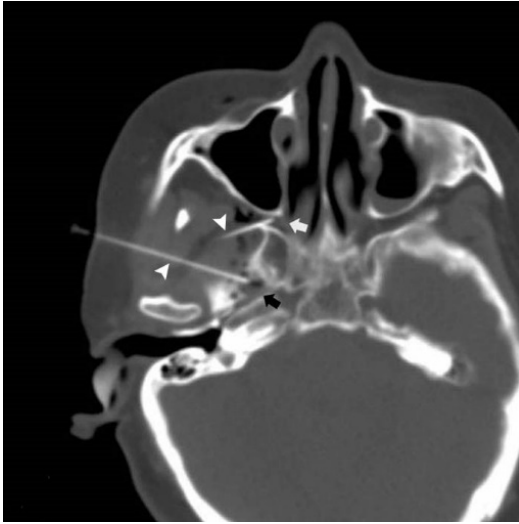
Axial computed tomography (CT) image showing the needle (White arrowhead) tip at the pterygopalatine fossa (PPF) (White arrow) and foramen ovale (FO) (Black arrow). Distribution of ozone gas can be seen.
